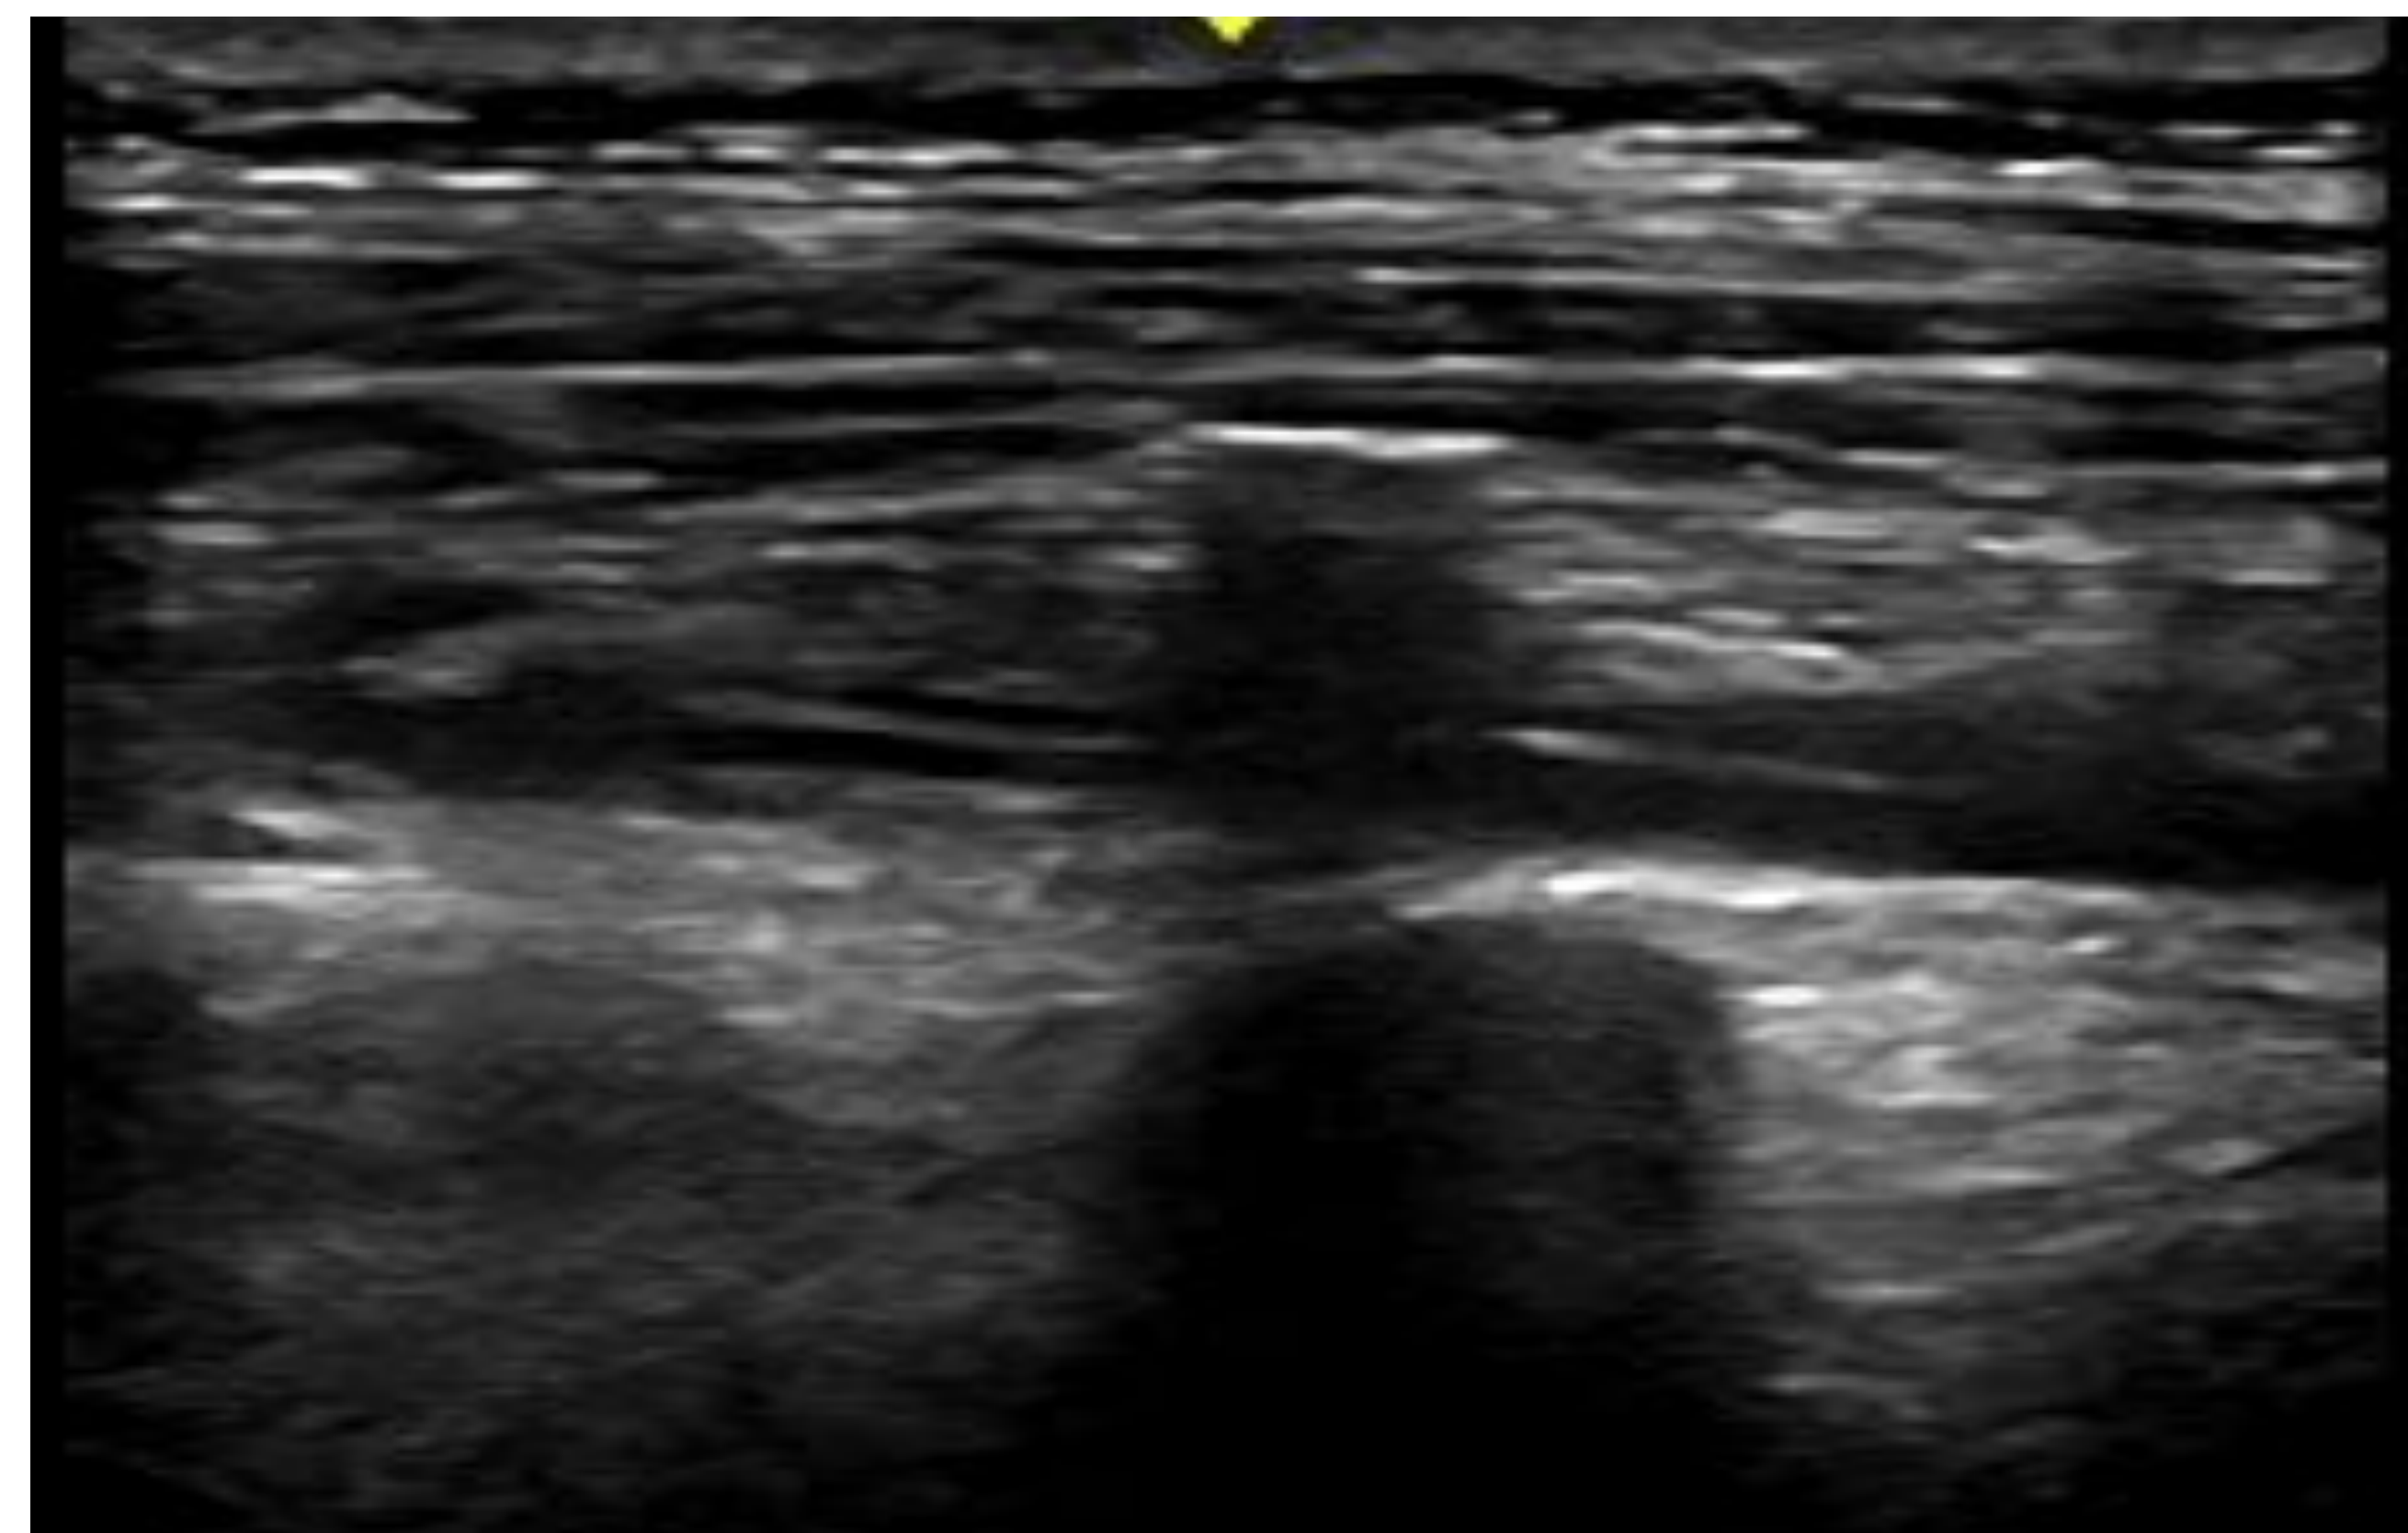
Ultrasound imaging of the Erector Spinae Block with evidence of anesthetic spread.
